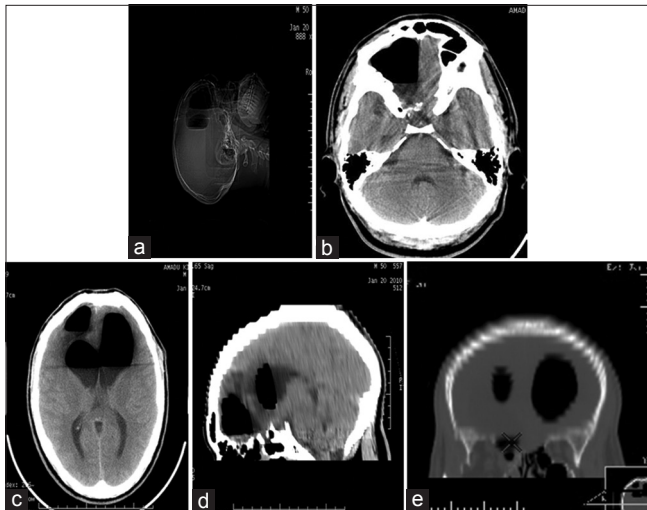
(a) Scanogram of Case 2 demonstrating skull lucencies with air-fluid levels in the supine position. (b) Axial computed tomography showing pneumocephalus over the right frontal basal skull. (c) Tension pneumoventricles in both anterior horns. (d) Sagittal reconstructed image of Case 2. (e) Bone window showing coronal section of the anterior horns of both lateral ventricles and skull base, demonstrating fracture site, pneumocephalus and pneumoventricles in Case 2
